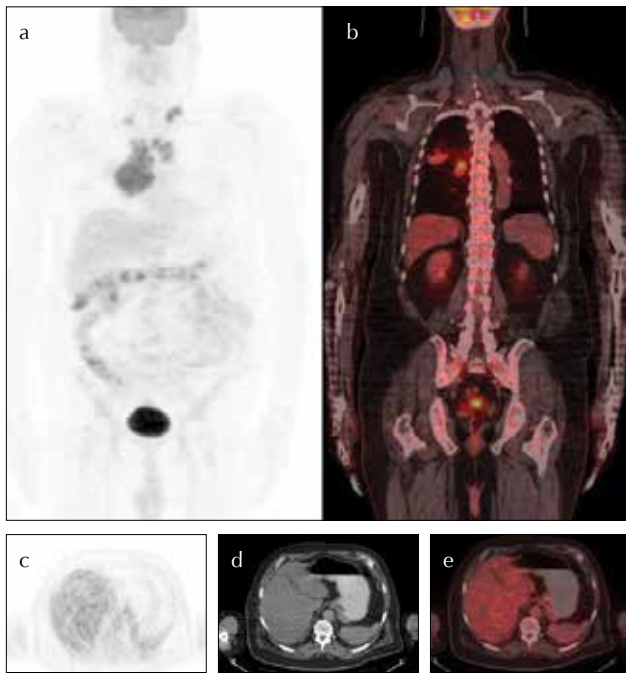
a-e. FDG PET/CT images of a 68-year-old patient with small cell lung cancer and accompanying pneumonia. The maximum intensity projection image (a) shows the primary 8-cm tumor in the hilum of the right lung and mediastinal, supraclavicular metastatic lymph nodes. The splenic FDG uptake was less than the hepatic FDG uptake, on coronal-fused FDG PET/CT (b), axial PET (c), CT (d), and axial fused PET/CT (e) images. The calculated SUVmax of the involving regions was as follows: TmSUVmax: 15.3, SSUVmax: 2.7, LSUVmax: 3.1, BMSUVmax: 3.5. S/L and BM/L were calculated as, 0.87, 1.1, respectively. Laboratory findings were as follows: WBC, $8.9 \times 10^3/\mu\text{L}$; Neu, $5.5 \times 10^3/\mu\text{L}$; Hb, 13.9g/dL; Htc, 41%; Erit, $4.6 \times 10^6/\mu\text{L}$; CRP, 3.03 mg/dL
